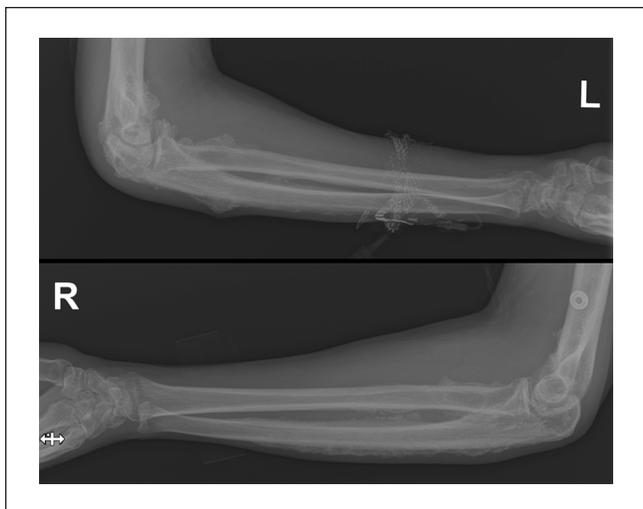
X-rays of the left and right forearms depicting prominent osseous proliferation along the elbows, radii, and ulnas.
